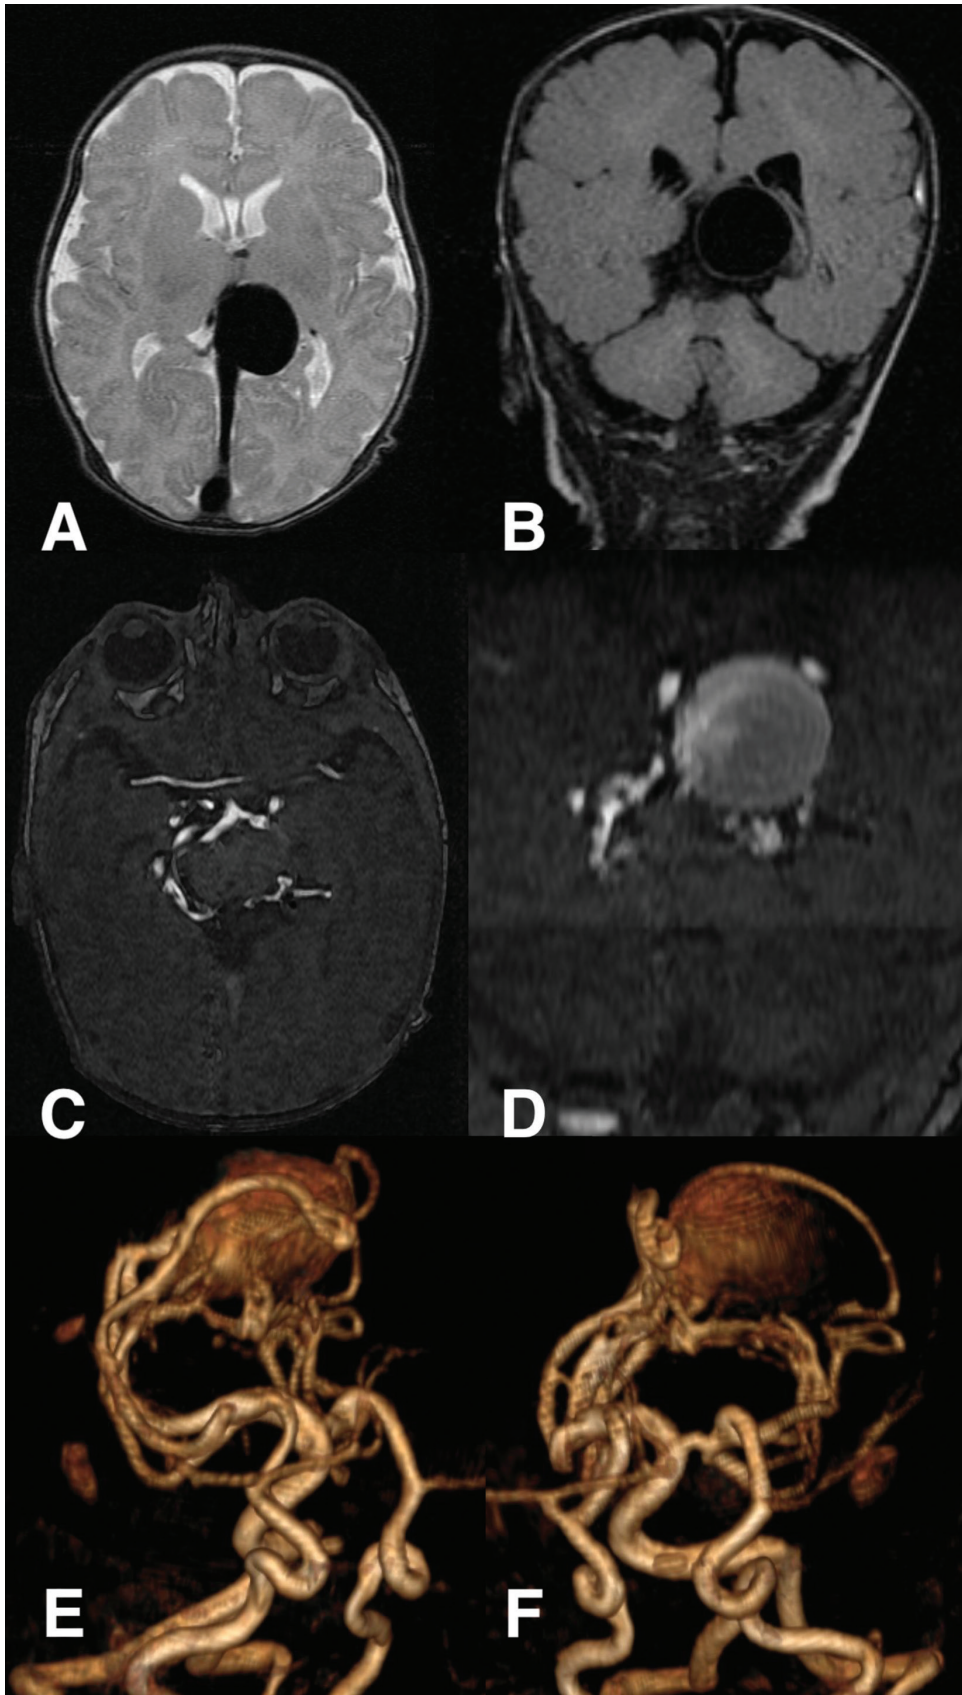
MRI at the age of 1 month. Axial T2 weighted and coronal FLAIR images of the brain show dilatation of the vein of the Galen up to 3 cm in diameter without any pathological findings in the brain parenchyma and ventricular system (A, B). 3D TOF images with VR reconstructions demonstrate the feeders coming from the posterior and middle choroidal arteries draining into the large aneurysmal dilatated vein of Galen (C, D, E, F).
